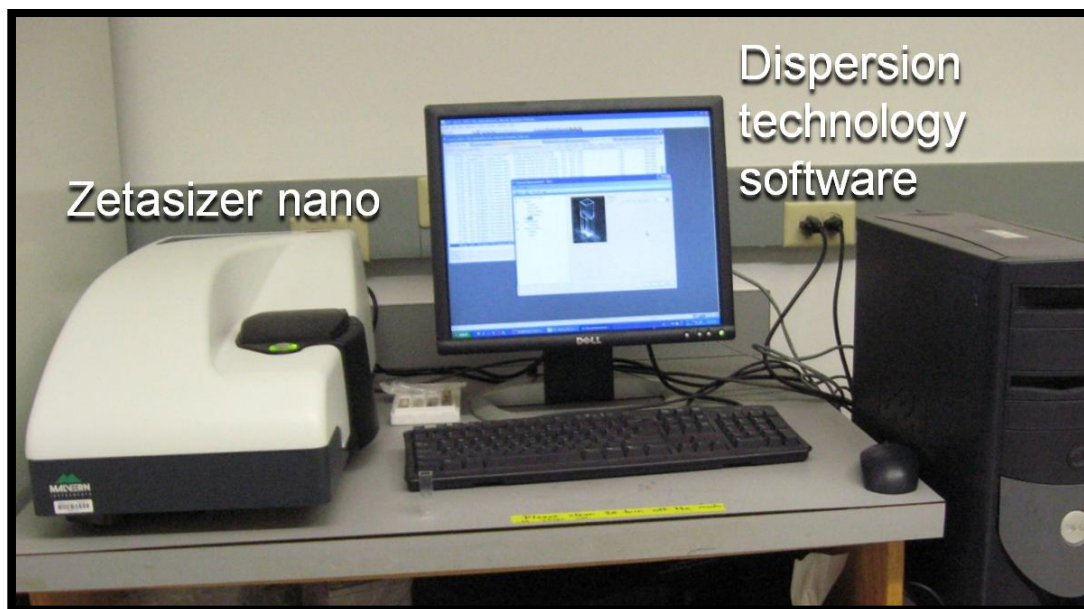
Zetasizer nano and dispersion technology software (Malvern Instruments) uses dynamic light scattering to determine particle sizes (0.3 nm diameter to 10 μm) and samples dilute to 100 $\mu\text{g/ml}$ (determined for proteins). The same apparatus can also be used for zeta potential measurements if also equipped with laser doppler microelectrophoresis.
